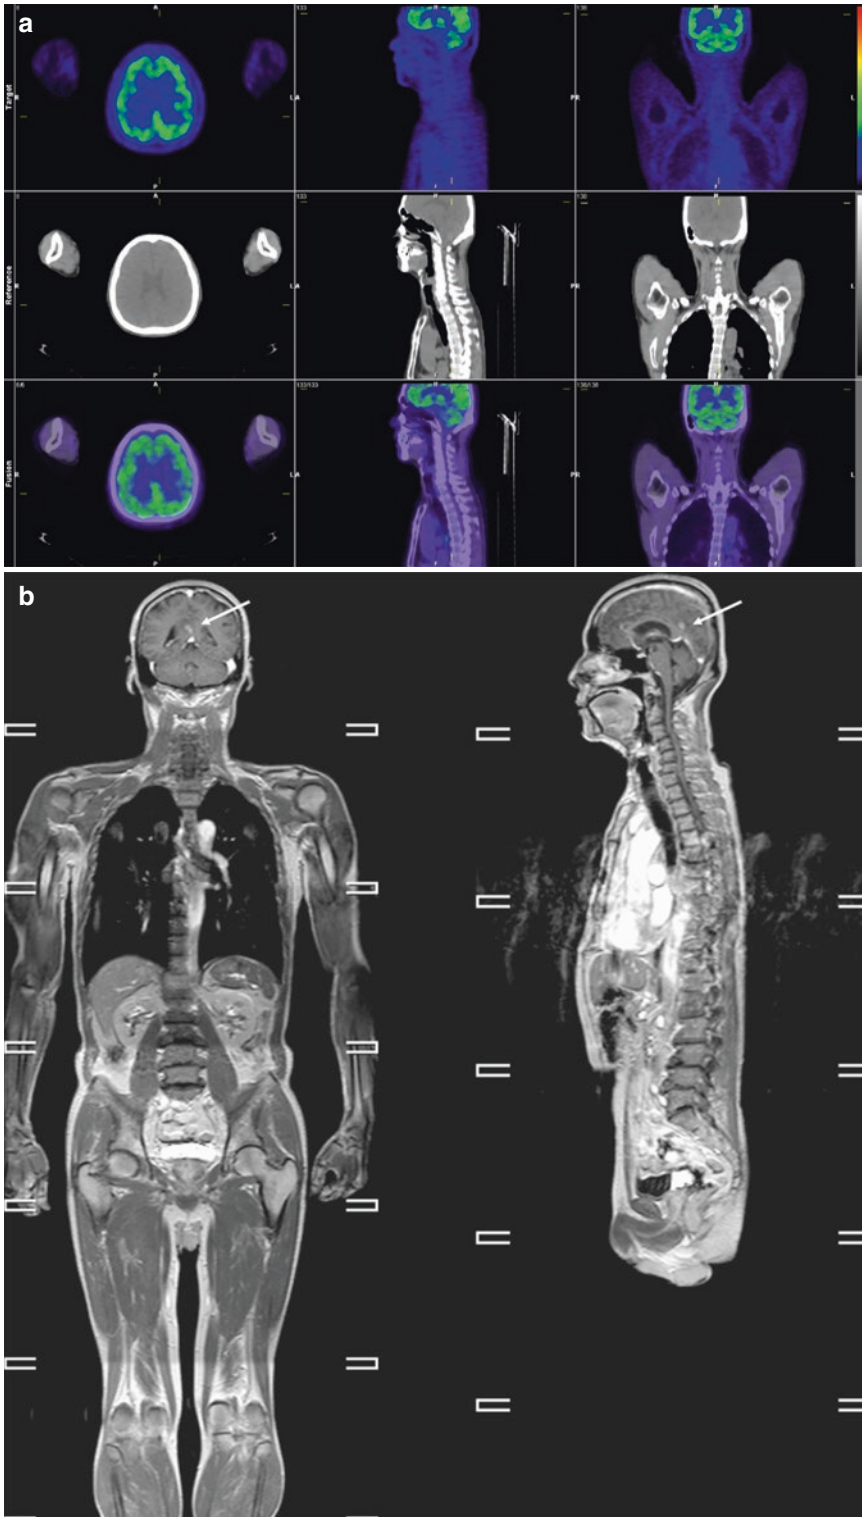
A 67-year-old male with adenocarcinoma and brain metastasis. Integrated FDG-PET/CT (a) does not show any abnormal uptake, suggesting M0, which was
